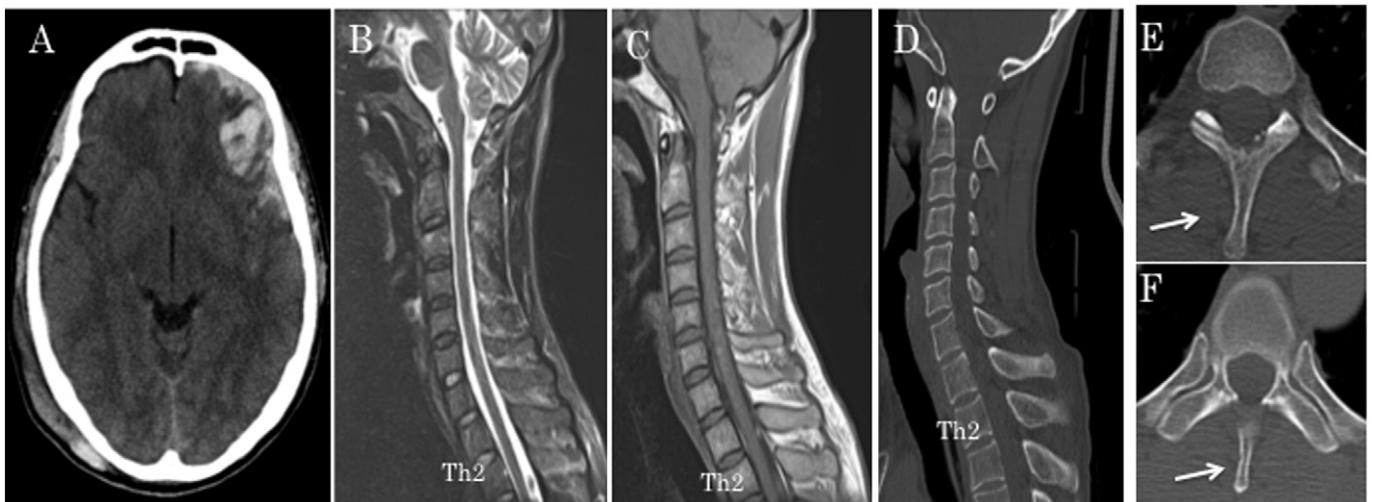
Axial cranial CT image on admission demonstrating cerebral contusional hemorrhage (A). Sagittal T1, T2-weighted magnetic resonance (MR) images (B and C) and sagittal CT image of cervical spine (D) revealed no apparent lesion. In axial CT image at the level of Th2 and Th3 (E and F), a small crack in spinous process was suspected (arrow).
